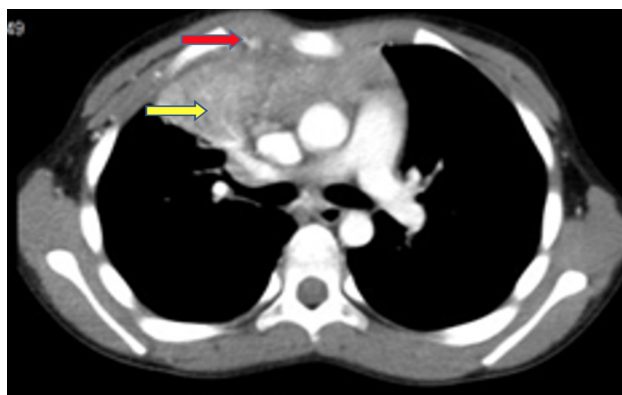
Contrast enhanced CT thorax showing a heterogeneously enhancing anterior mediastinal mass which seems to conform to an enlarged thymus gland. There is infiltration to the right anterior chest wall (red arrow). A collapsed consolidation of the right upper lobe is also observed (yellow arrow)
